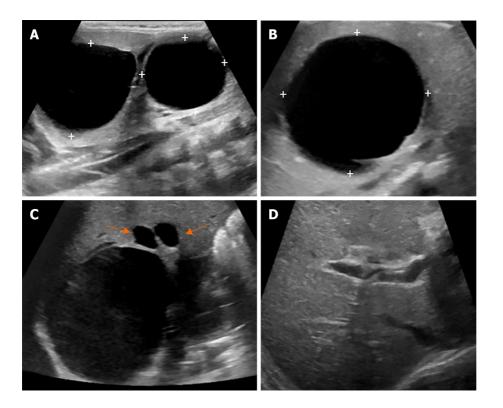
A term female infant with hepatic cyst detected by prenatal ultrasonography, presented with jaundice since birth. Repeated abdominal ultrasonography showed fusiform dilatation of extrahepatic and intrahepatic bile ducts, 3.3 cm × 4.5 cm, suggestive of choledochal cyst type IVa (Todani's classification), containing bile sludge, and another large hepatic cyst in segment IV, 4.7 cm × 4.3 cm. After conservative treatment, clinical jaundice progressed. Liver function test showed total bilirubin/direct bilirubin (TB/DB) of 10.9/1.68 mg/dL, aspartate aminotransferase of 45, alanine aminotransferase of 23, alkaline phosphatase of 150, gamma-glutamyltransferase of 172 U/L, and albumin of 3.9 mg/dL. Computed tomography revealed a cystic lesion measuring 3.7 cm × 5 cm × 4 cm, at the common bile duct area, slight bilateral intrahepatic duct dilatation, a smooth thin wall hypodense lesions measuring 5.1 cm × 4.6 cm × 4.3 cm at hepatic segment 4a/8, and a few small hypodensity lesions at segment 7 that were suspected to be an infected hepatic cyst. After percutaneous aspiration of the hepatic cyst and intensive antibiotics, the cyst enlarged to 5.4 cm × 5.8 cm. Finally, choledochal cyst excision with Roux-en-Y hepaticojejunostomy of the subcutaneous limb was performed. One year later, ultrasonography revealed a reduction in the size of the lobulated cystic lesion to size 2.9 cm × 2.8 cm × 2.1 cm and mild dilatation of the intrahepatic bile ducts at the porta hepatis region. A: Fusiform dilatation of the extrahepatic cyst and intrahepatic bile ducts, measuring 3.3 cm × 4.5 cm, containing bile sludge; B: Another large cyst, 4.7 cm × 4.3 cm, in hepatic segment IV; C: Decreased size of the lobulated cystic lesion at the porta hepatis region with a few small hypoechoic lesions surroundings the cystic lesion, probably cysts or focal IHD dilatation; D: Mild dilatation of the intrahepatic bile ducts at the porta hepatis region.
